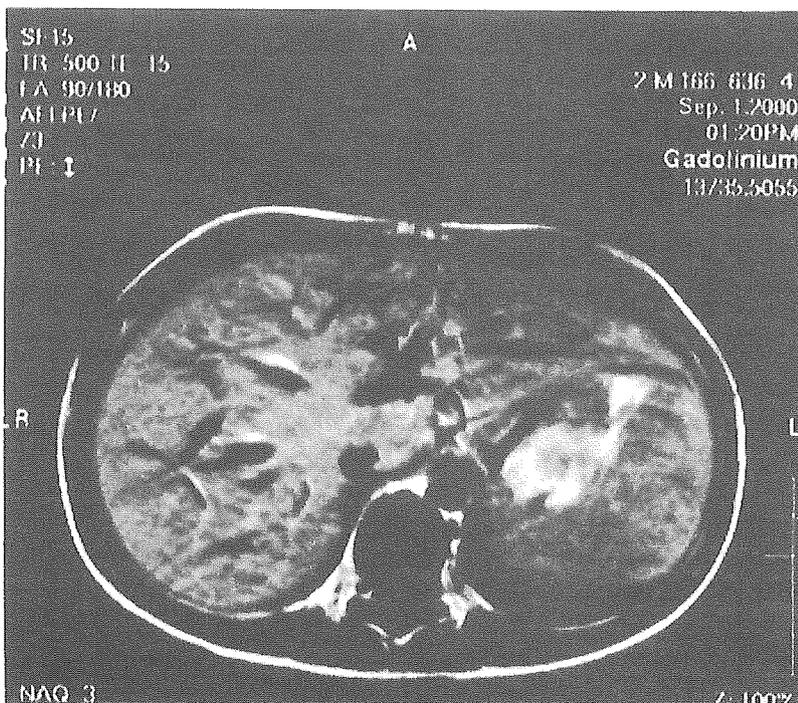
Magnetic resonance imaging clearly outlines a tumor of high signal intensity on gadolinium-enhanced T1-weighted images (T1WI) 2 years after the first operation
